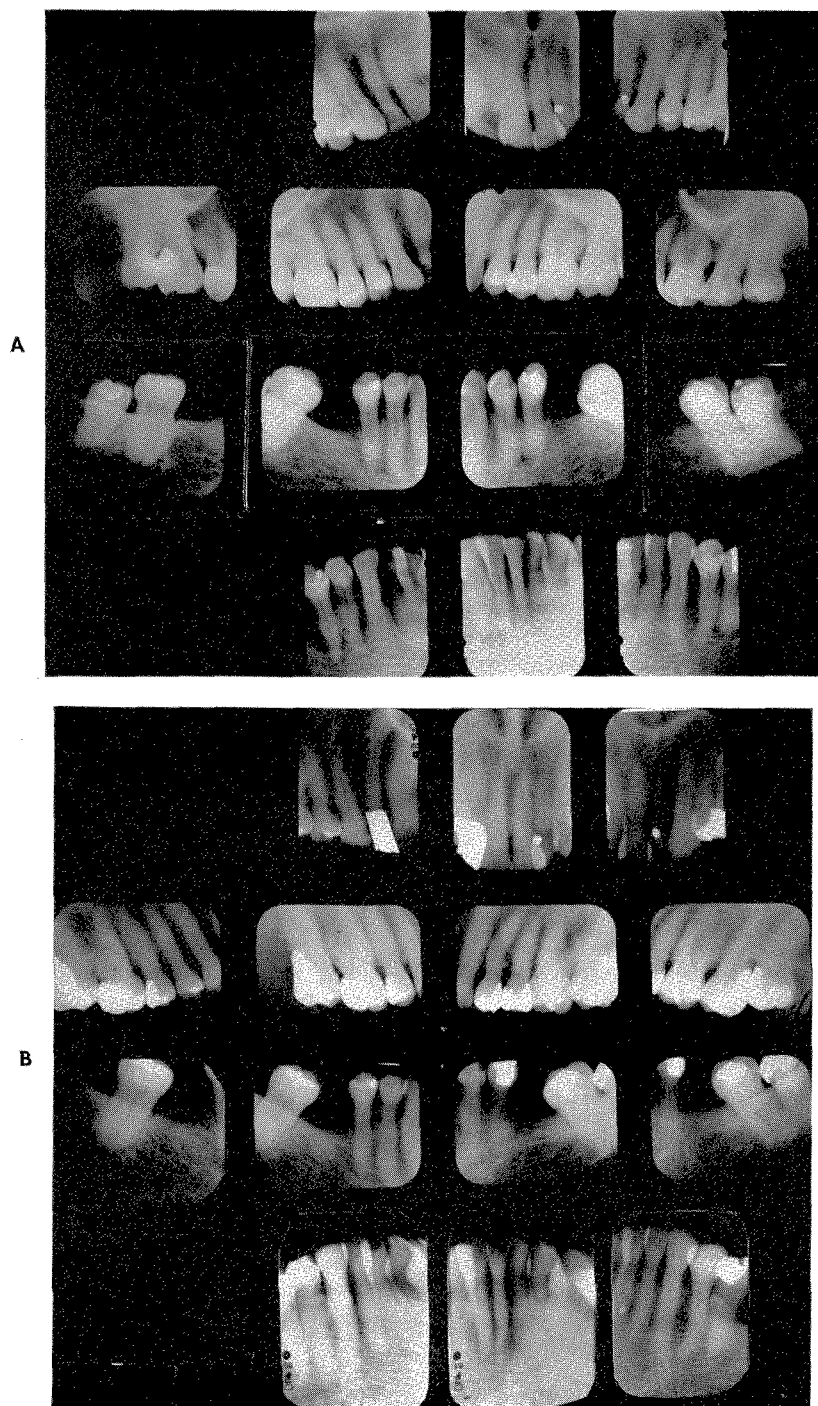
A, Roentgenograms of the patient taken in June, 1939. She was 63 years old at this time. B, Roentgenograms of the patient taken in 1959 at the age of 83. Only the right third molars were removed in the twenty-year period between the two series. The structures had deteriorated very little.
